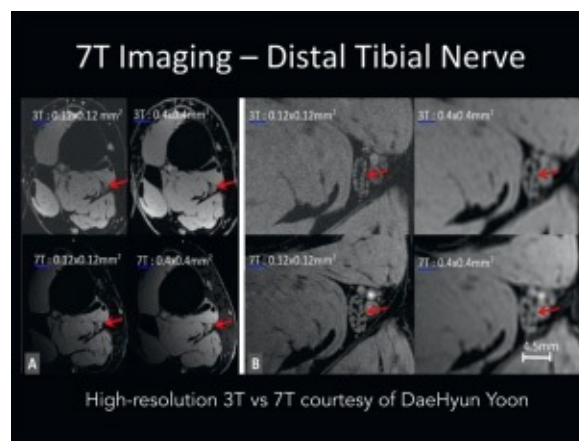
• Comparison of 3T and 7T MRI of tibial nerve. (Courtesy of Daehyun Yoon, Stanford University.)
